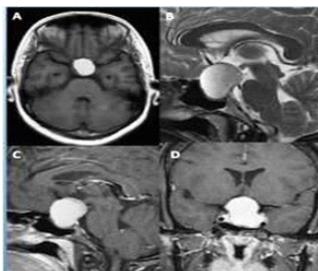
MRI: T1W2 showing pituitary micro-adenoma with hyperintense not enhancing content
